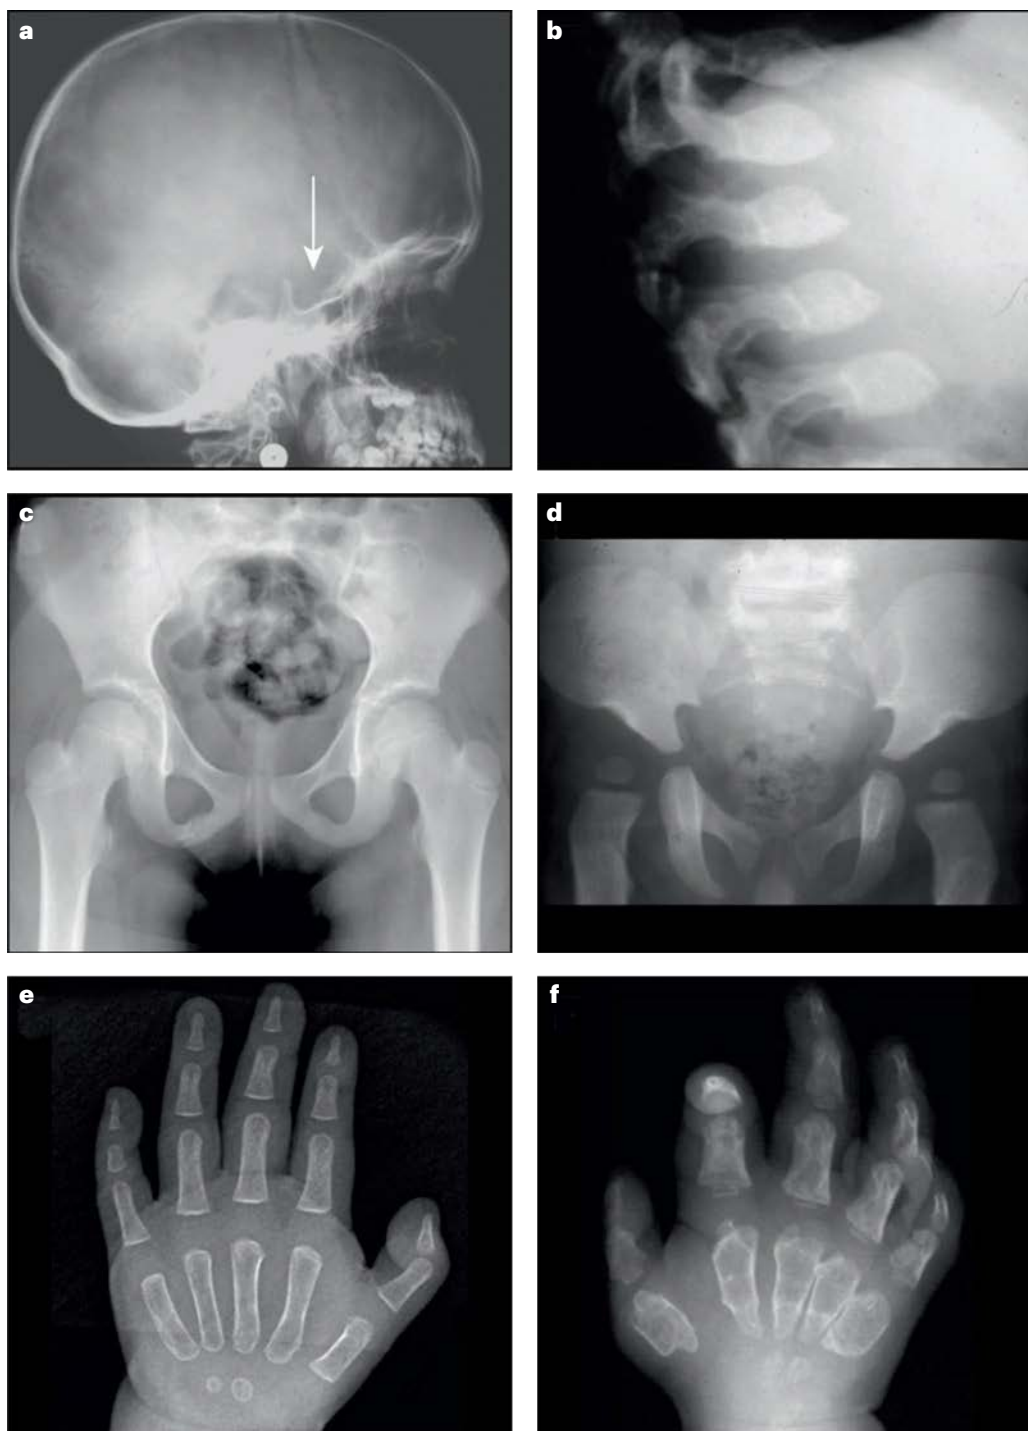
Typical radiographic findings of dysostosis multiplex. a–f, Characteristic skeletal abnormalities in dysostosis multiplex. Panel a shows a lateral skull radiograph with a characteristic ‘J-shaped’ sella turcica (arrow). In panel b, a lateral view of the spine reveals oval-shaped vertebral bodies with inferior ‘beaking’. Panel c presents a normal anterior–posterior view of a pelvis for comparison. In panel d, the pelvis demonstrates the classic ‘wine glass’ appearance, marked
